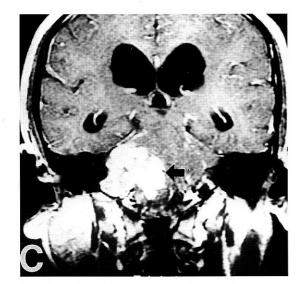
The irregularly enhanced mass(arrow) lesion compresses the brain stem on right cerebellopontine angle. Brainstem is shifted to the left side (T1-weighted enhanced image).
